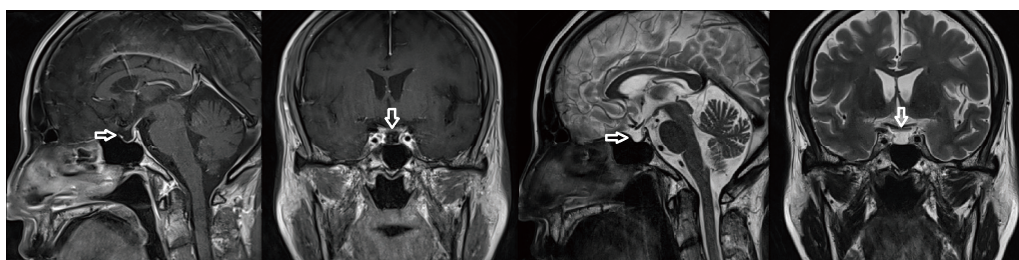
Sagittal and coronal view on magnetic resonance image. Arrow showing empty sella turcica filled with CSF.
